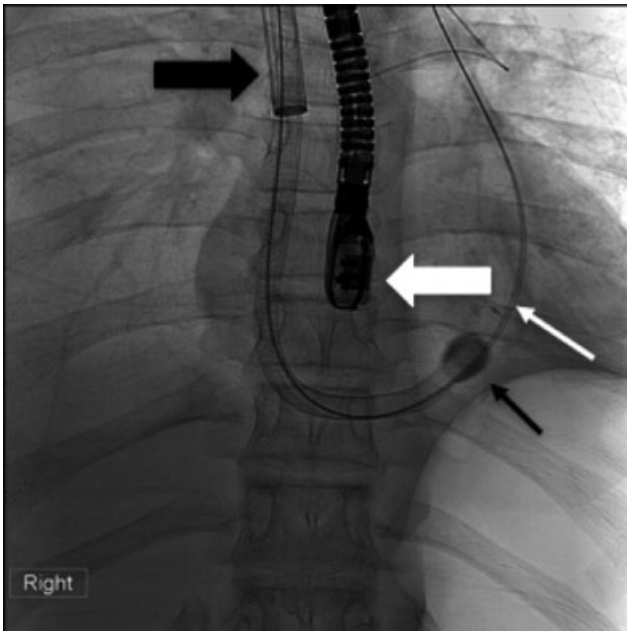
Intraprocedural fluoroscopic image demonstrates a 22Fr sheath (large black arrow) through a right internal jugular access over a stiff wire (small white arrow) that has been navigated through the right atrium, right ventricle, and into the main pulmonary artery. The AngioVac aspiration cannula (small black arrow) has been advanced over the stiff wire into the right ventricle using transesophageal echo (large white arrow) and fluoroscopic guidance.
